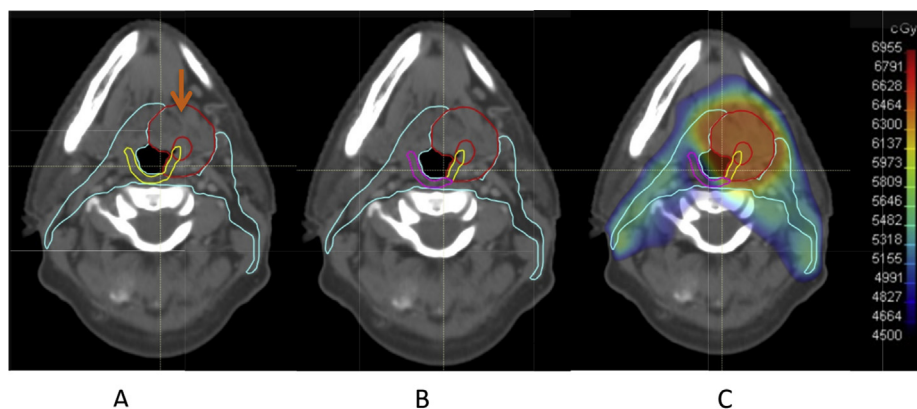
(A) Axial computed tomography scan showing gross tumour volume (red), clinical target volume (CTV1) for radical dose radiotherapy (red with arrow), CTV2 for prophylactic dose radiotherapy (cyan), superior/middle pharyngeal constrictor (SMPCM; yellow). (B) SMPCM lying outside CTV1 edited to create PlanSMPCM (pink). (C) PlanSMPCM is set a mean dose constraint of <50 Gy in the planning objectives.
